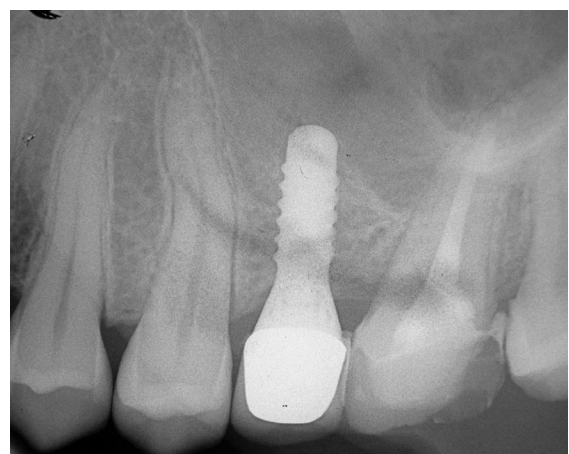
X-ray 36 months after prosthesis.
